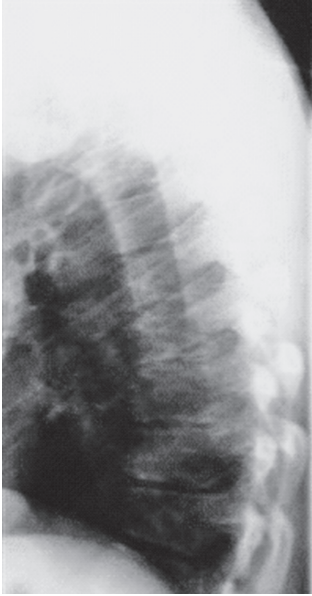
X-ray of thoracic spine in lateral projection [14]
